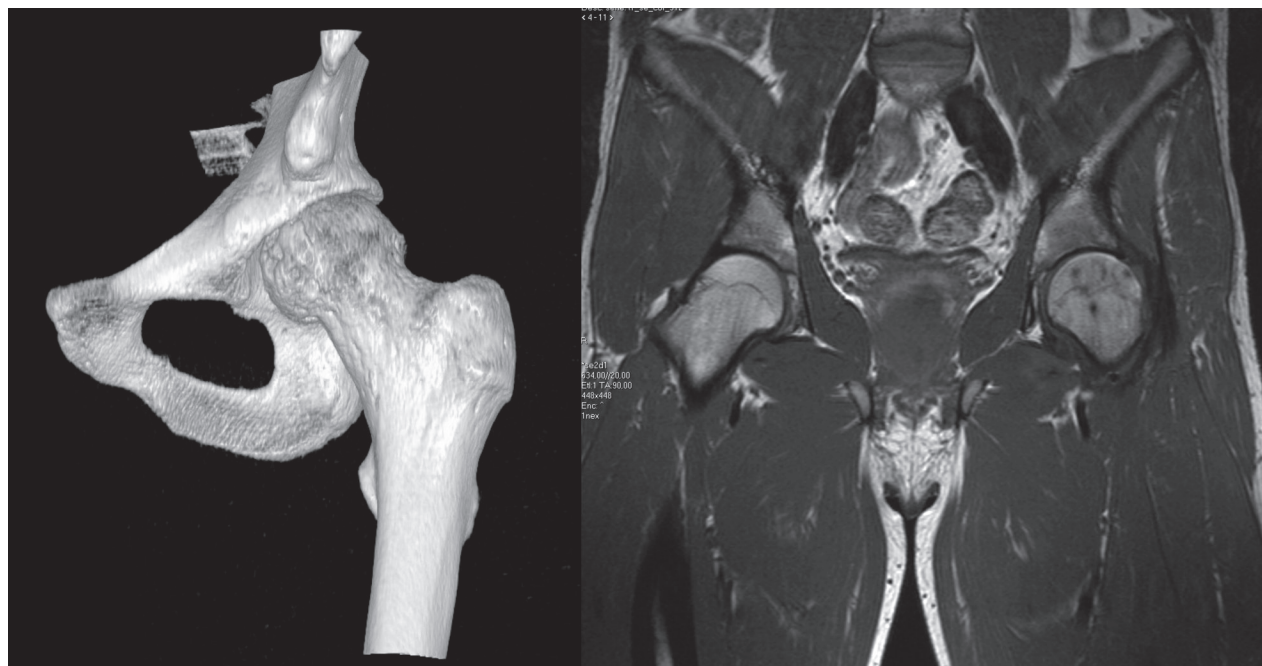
4-year follow up 3D CT scan and MRI showing bone healing with no signs of avascular femoral necrosis
